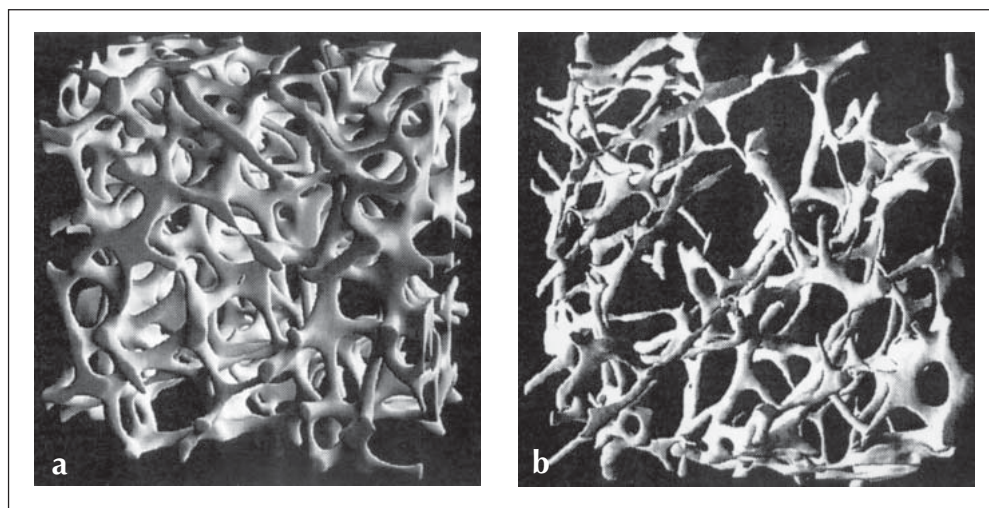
Normal (1a) and osteoporotic (1b) bone structures (cancellous bone, vertebra) ( $\mu$ CT 20, Scanco Medical Ltd., Zurich).
